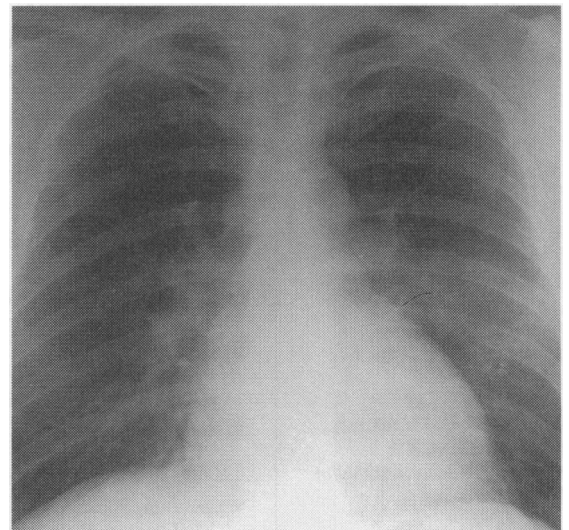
Radiograph showing influenza pneumonitis
